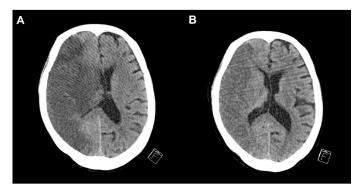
Distance from the midline to the pineal body. A: CT image in 2^{nd} day after stroke onset (9.8mm) B: CT image in 10^{th} day after stroke onset (2.1mm)
